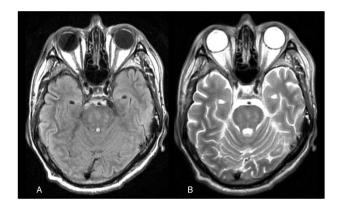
Brain MRI (A. FLAIR, B. T2) in axial sections at the pontine level; the predominant involvement of the transverse pontine fibres and the relative sparing of the descending corticospinal tracts are responsible for this hyperintense image with the characteristic "trident sign."
